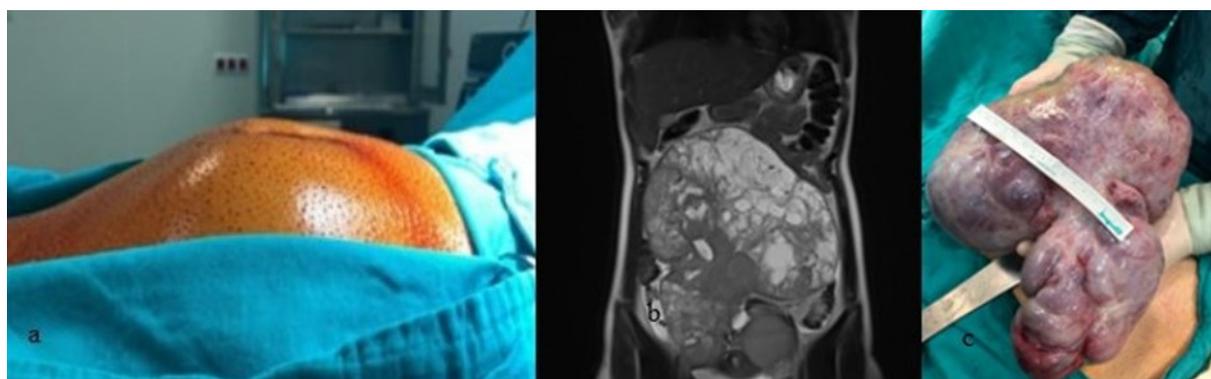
3a: the appearance of the abdomen before the operation by inspection in the third case; 3b: MRI imaging; intra-abdominal mass extending from symphysis pubis to xiphoid process; 3c: The postoperative appearance of the mass, with a diameter of 30 cm semisolid mass.
